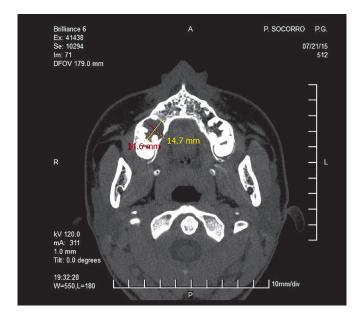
Cone-beam computed tomography in axial section.
